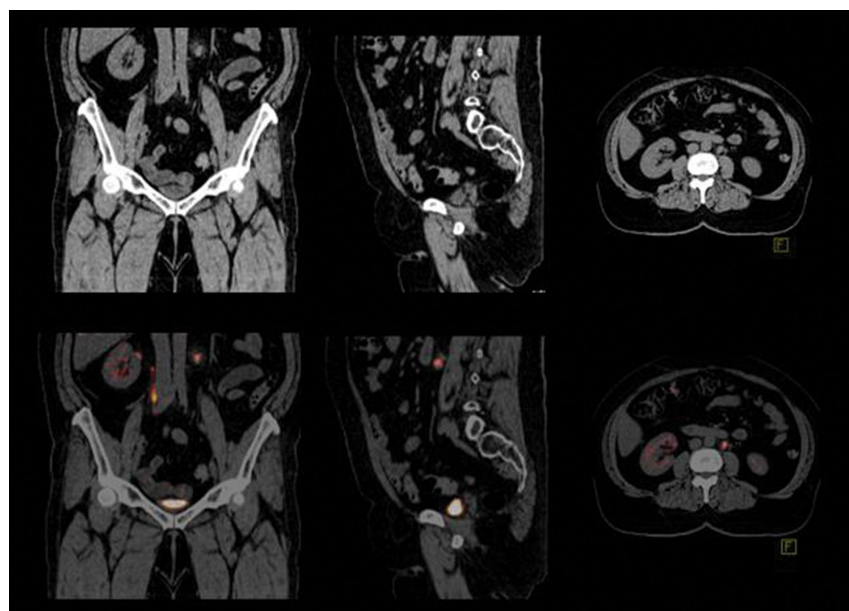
Thin-slice CT and fused PET/CT images help delineate small solitary hypermetabolic left para-aortic nodal metastases.
